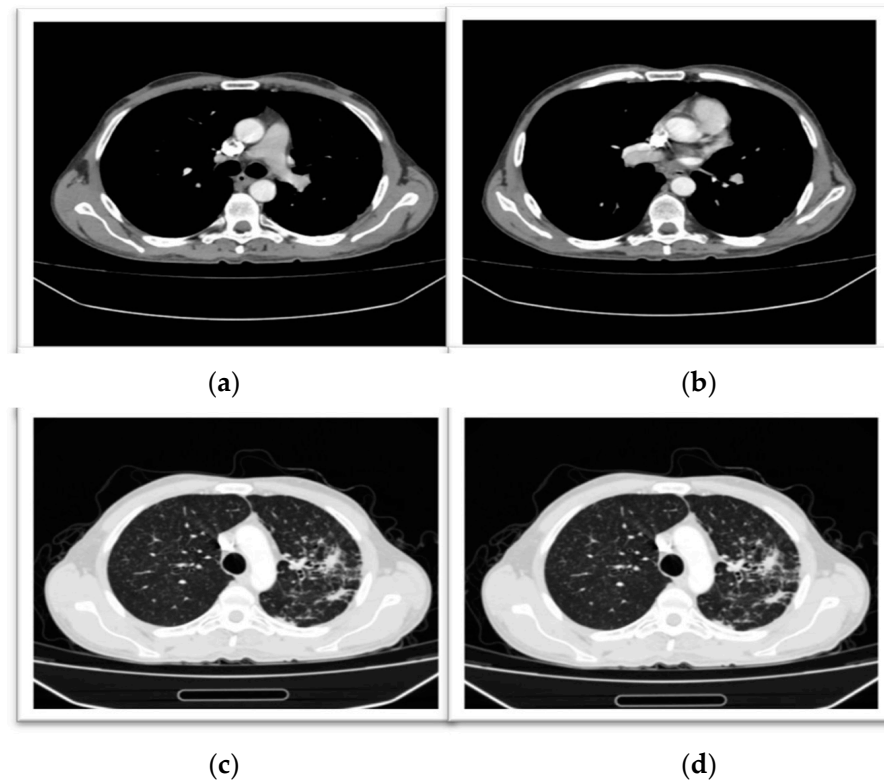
CT pulmonary angiography showing bilateral pulmonary arterial filling defects, interpreted as pulmonary embolism, involving lobar and segmental branches (a). Pulmonary arterial enhancement was suboptimal (b), which limited thrombus conspicuity on the reproduced image.
